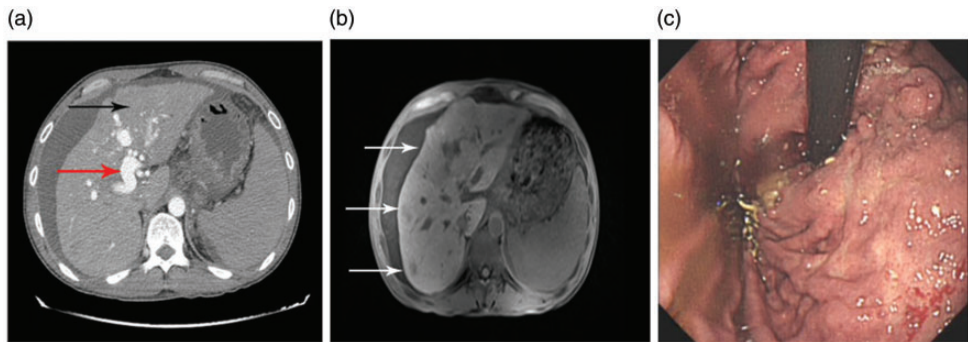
Contrast-enhanced CT, MRI and upper gastrointestinal endoscopy findings in a 31-year-old man with hepatocellular carcinoma and severe APS. (a) CT showed a huge mass measuring approximately 7 cm in diameter in the left hepatic lobe (black arrow). The lesion was unenhanced in the arterial phase because the tumorous APS reduced arterial blood flow. A hyper-enhanced portal vein was present in the arterial phase CT image (red arrow). CT images also identified ascites and splenomegaly. (b) MRI in our hospital showed multiple hypodense parenchyma masses (white arrows, liver segment 4,5,6), similar to the outside hospital CT scan. (c) Upper gastrointestinal endoscopy revealed severe esophagogastric varices. CT, computed tomography; MRI, magnetic resonance images; APS, arteriportal shunt.
